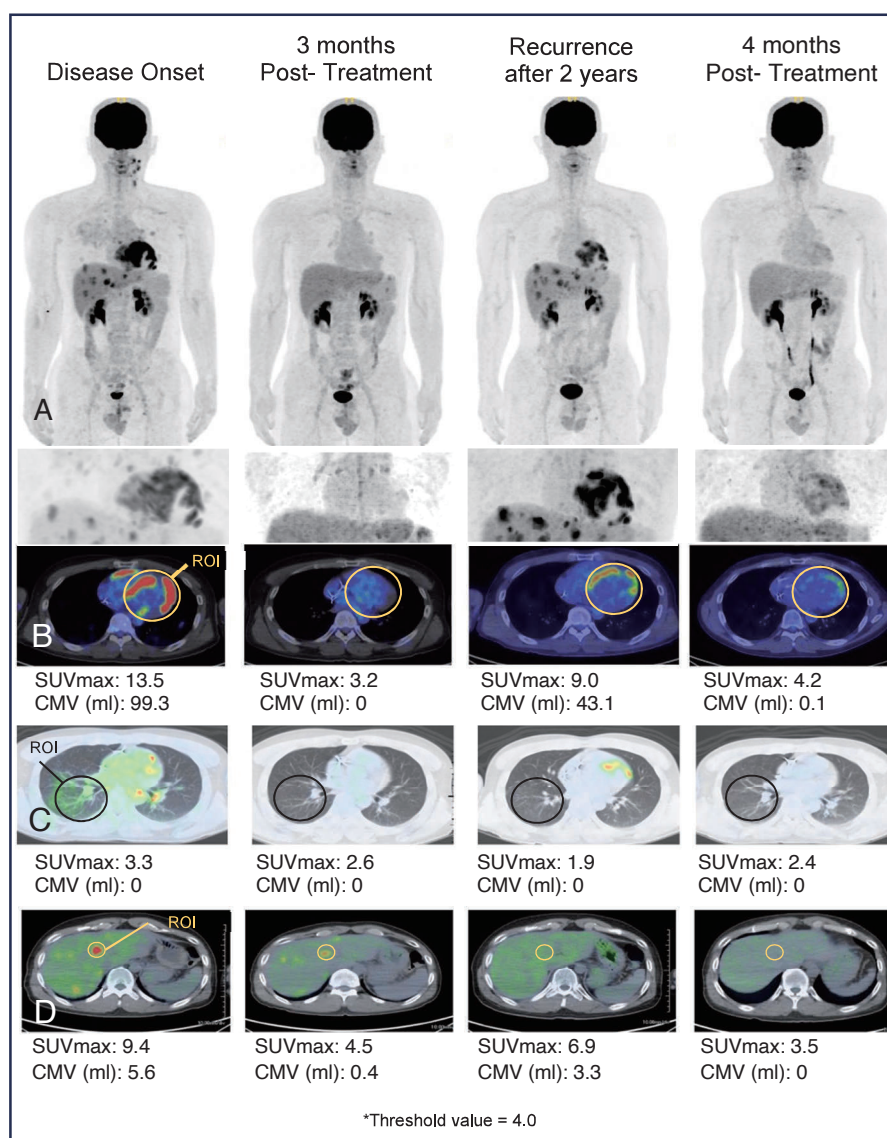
Case 1: A male patient in his 30s with clinically diagnosed cardiac and extracardiac sarcoidosis developed a recurrence of disease 2 years after an initial treatment. (A) Serial MIP of the whole body and chest, along with ^{18}F -FDG PET/CT images featuring SUVmax and CMV analysis of the (B) heart, (C) lung, and (D) liver were performed to document the statuses at disease onset, post-treatment, on follow up, and after a second round of therapy due to recurrence. Corticosteroids are the first line of treatment for sarcoidosis and have been recognized to improve overall disease control, especially with pulmonary sarcoidosis. Indices such as SUVmax and CMV provide objective markers for inflammatory and metabolic activity. (B, D) The observed reduction in SUVmax and CMV post-treatment correlates with response to treatment and control of active inflammation. At the same time, persistently low SUVmax and CMV (D) suggest no active inflammation or a chronic fibrotic stage.
